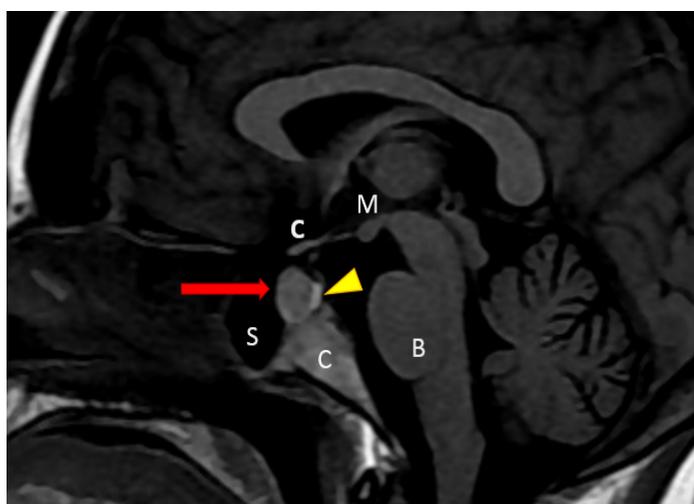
This is an imaging report of a 29-year-old pregnant female. The sagittal T1-weighted non-contrast image of the pituitary fossa demonstrates the anterior pituitary tissue (indicated by the red arrow) visible within the sella, along with the posterior pituitary bright spot (indicated by the yellow arrowhead) located behind it. Additionally, the suprasellar region displays the optic chiasm, C, and mamillary bodies, M. Other notable structures observed in the image include the brainstem (B), sphenoid air sinus (S), and clivus (CL).
